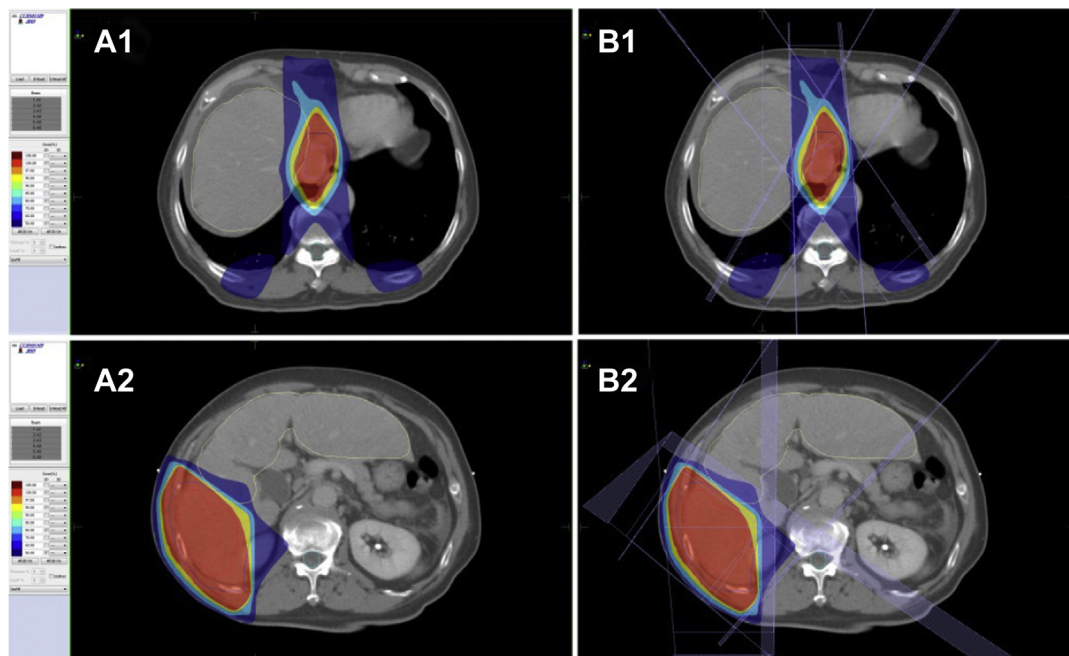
Computed tomography scans of our patient with hepatocellular carcinoma showing dose distribution of radiation from proton beam therapy (A) and that from standard X-rays using the same beam arrangement (B). The 100%, 95%, 80%, and 50% isodose lines are represented in red, yellow, light blue, and dark blue, respectively. The planning target volume (PTV) is represented in pink. The protocol required the PTV to be encompassed by the 95% dose envelope. (A1), (B1) On liver tumor. (A2), (B2) On portal vein. GTV = gross tumor volume.
